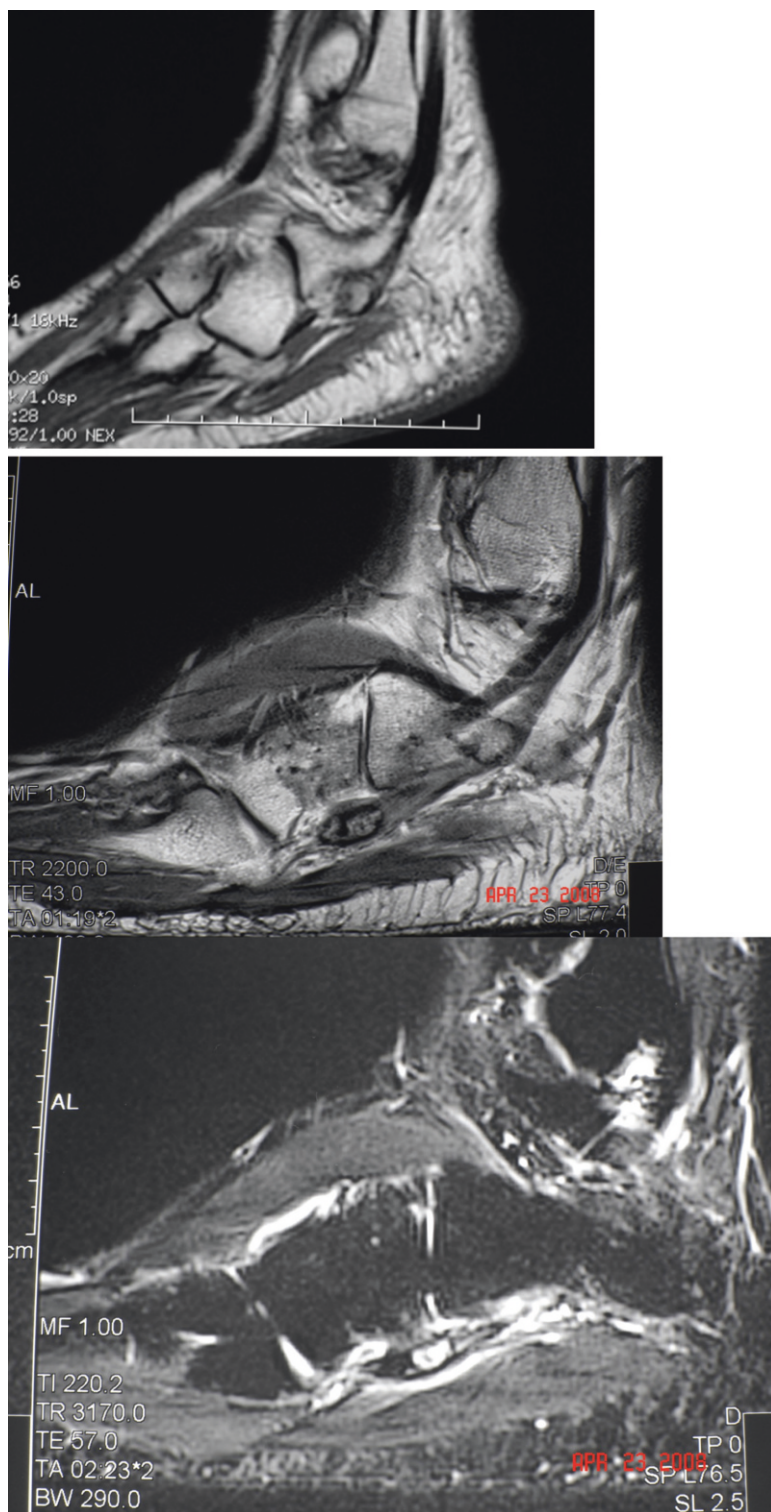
MRI sequences of a young athlete with lateral foot pain with activity. Imaging revealed the presence of an os peroneum on both T1- and T2-weighted sequences with corresponding increased signal intensity on T2 imaging
